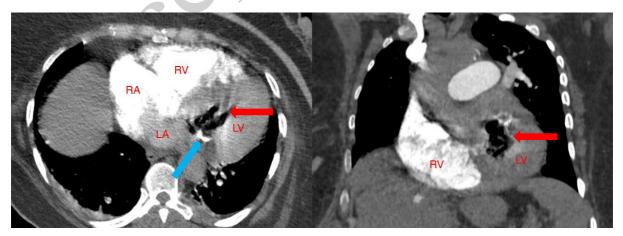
Right: Axial Pulmonary Angiography Computed Tomography (CTPA) showing an air containing lesion around the mitral valve (Red arrow). Note is made of mitral annual calcification (Blue arrow). Left: Coronal reformat demonstrating the air density lesion in the mitral valve (red arrow). RA: Right atrium, RV: Right ventricle, LV: left ventricle, LA: Left atrium
